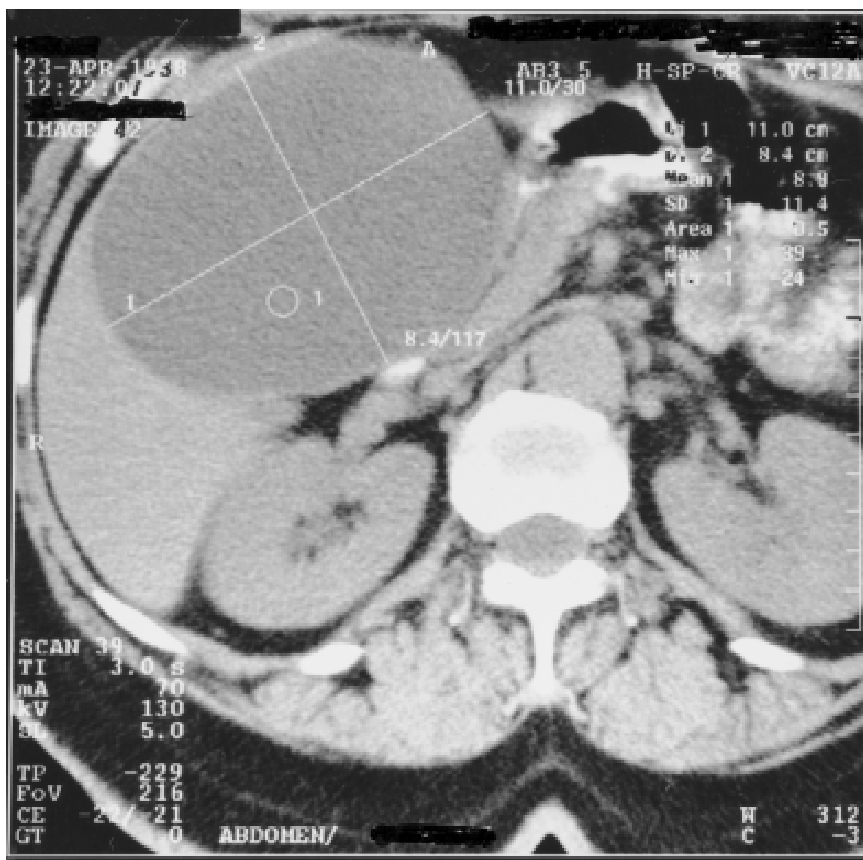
CT scan shows a well-encapsulated cystic mass (11 × 8 × 10 cm) between the right and left lobes of the liver, projecting inferiorly.
